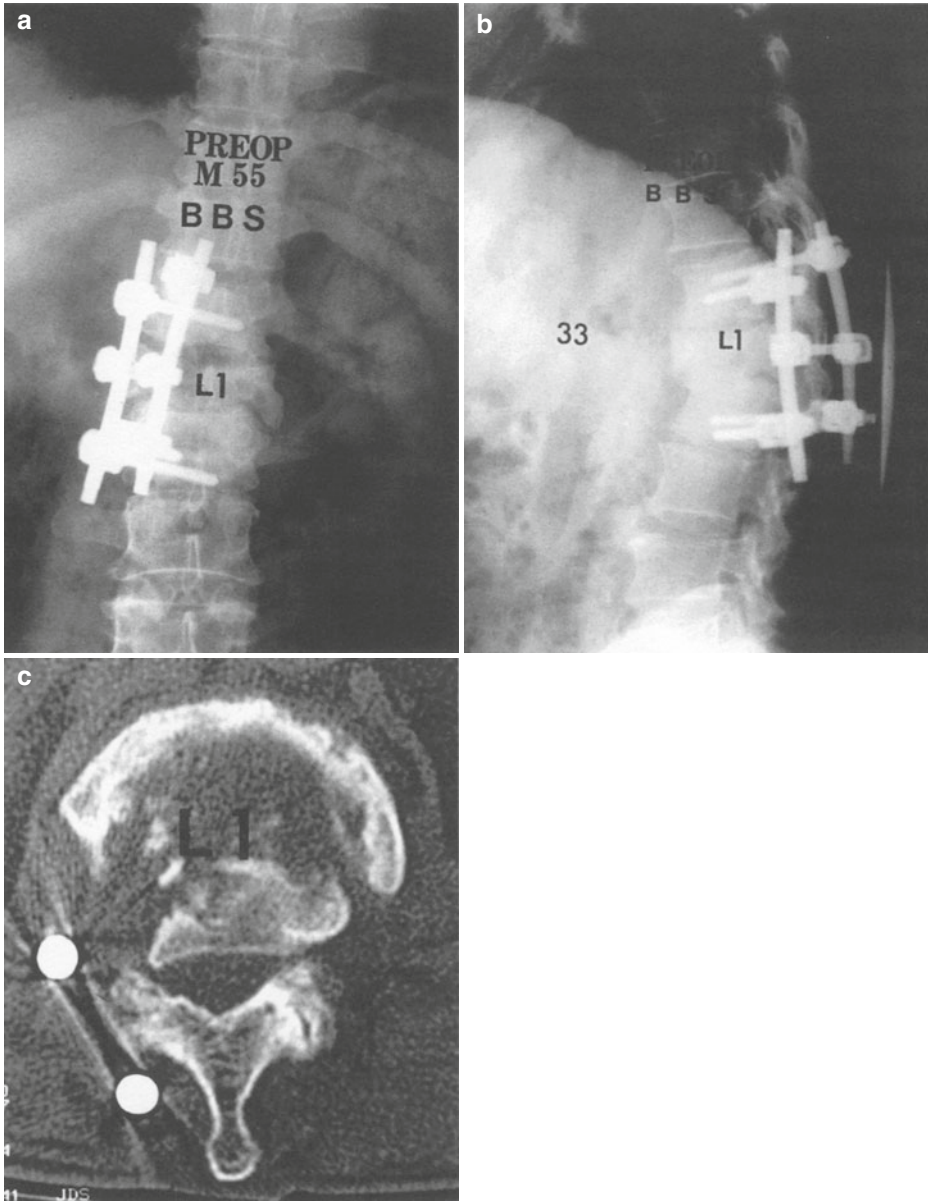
(a, b) A 68-year-old male with a post-traumatic kyphosis and cauda equina syndrome. One and half years prior to the visit, he sustained a burst fracture which was treated by posterior decompression and fusion. (c) Preoperative MRI show local kyphosis with canal
